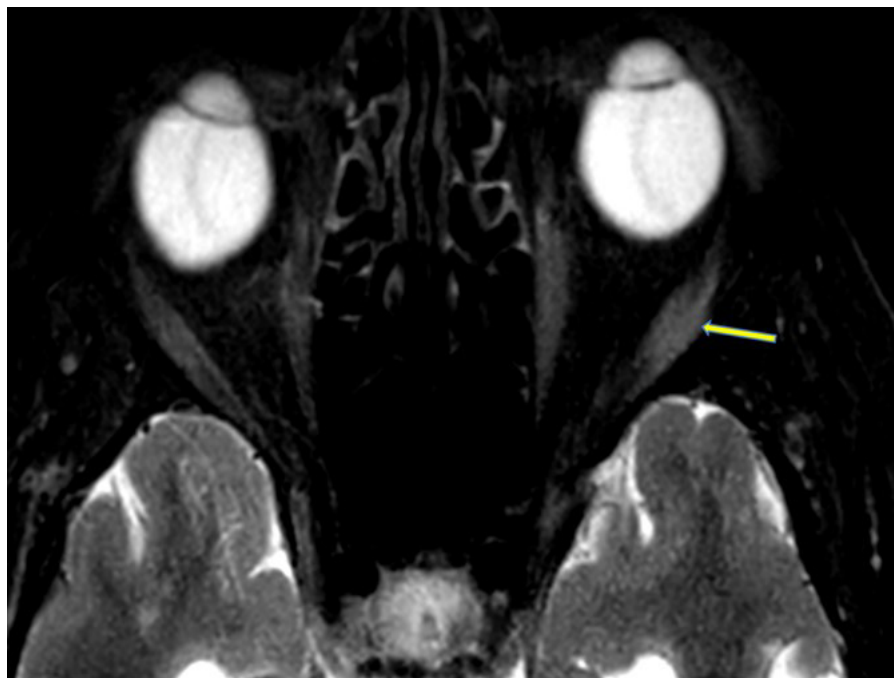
MRI Short Tau Inversion Recovery (STIR) axial image of both orbits showing enlargement and hyperintensity of the left lateral rectus muscle (arrow) with relative sparing of the tendon.
